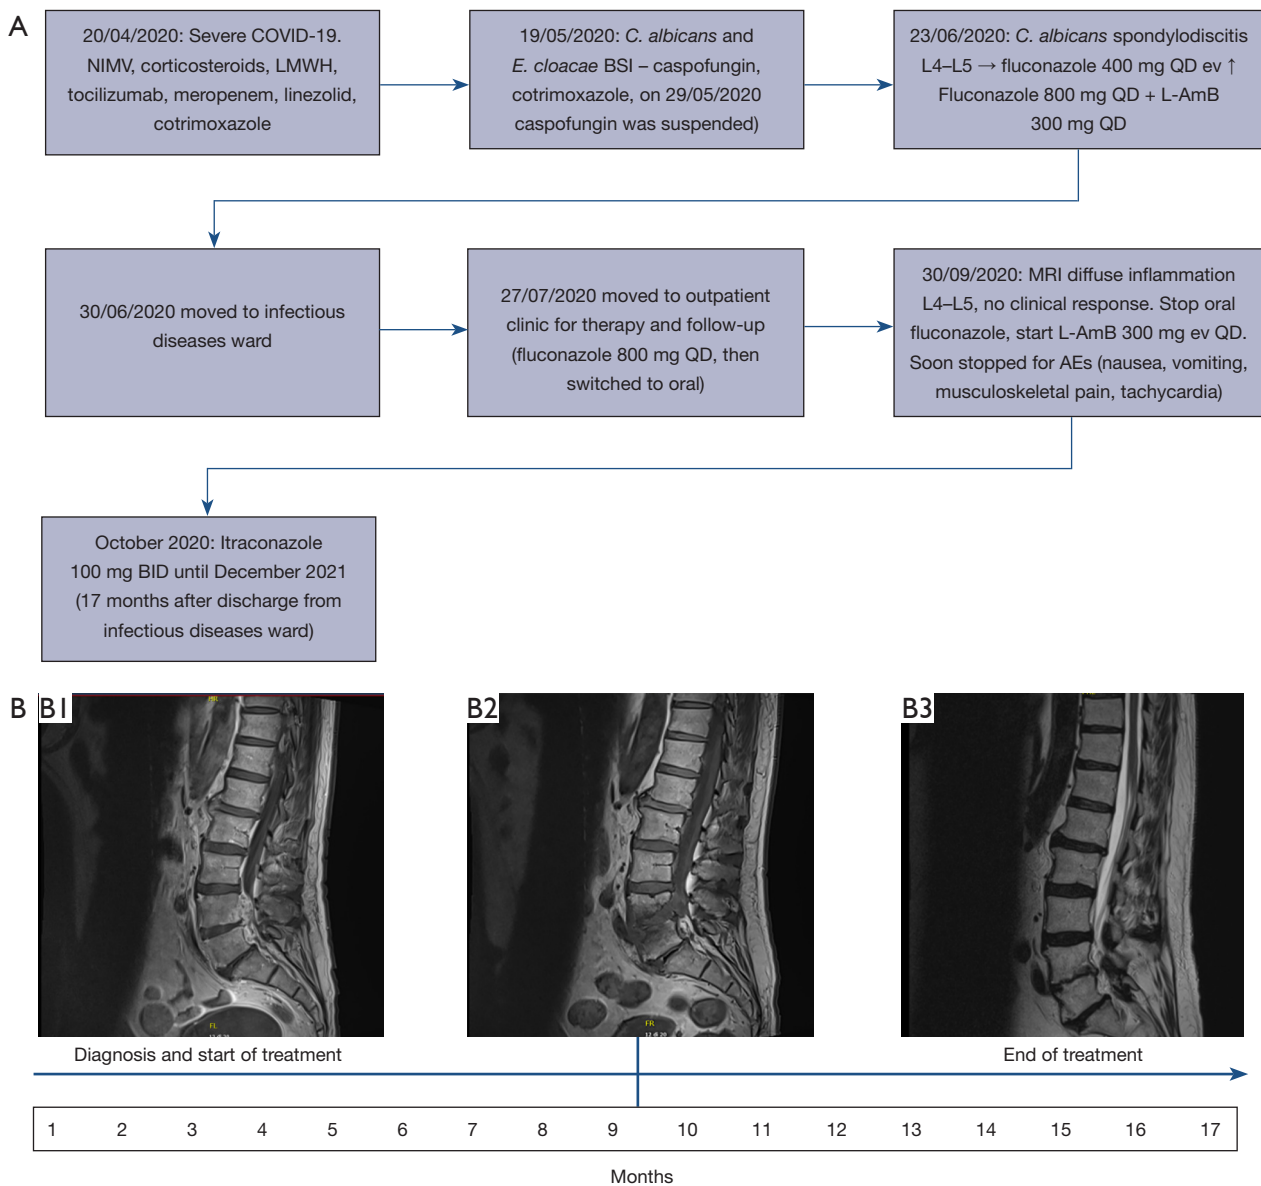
Timeline of the clinical, therapeutic and radiological progression of the CS in patient 1. (A) Timeline for patient 1. (B) Radiological evolution with RM of patient 1 at the start of the diagnosis (B1), after 8 months of therapy (B2) and at the end of treatment (B3) (left to right: 06/2020, 02/2021, 12/2021). This image is published with the patient/participant's consent. (B1) Extended alteration of signal involving L4–L5 vertebral bodies, partly involving the interposed disc, with contrast enhancement suggesting spondylodiscitis; (B2) compared to the former image, there is persistent L4–L5 alteration, with reduced contrast enhancement, which persists in the posterior part of L4–L5 bodies; (B3) persistence of known lesion, but without contrast enhancement, showing fibrotic and scar tissue. COVID-19, coronavirus disease 2019; NIMV, non-invasive mechanical ventilation; LMWH, low molecular weight heparin; *C. albicans*, *Candida albicans*; BSI, bloodstream infection; QD, once a day; ev, endovenous; L-AmB, liposomal amphotericin B; MRI, magnetic resonance imaging; AEs, adverse effects; BID, two times a day; ID, infectious diseases.
